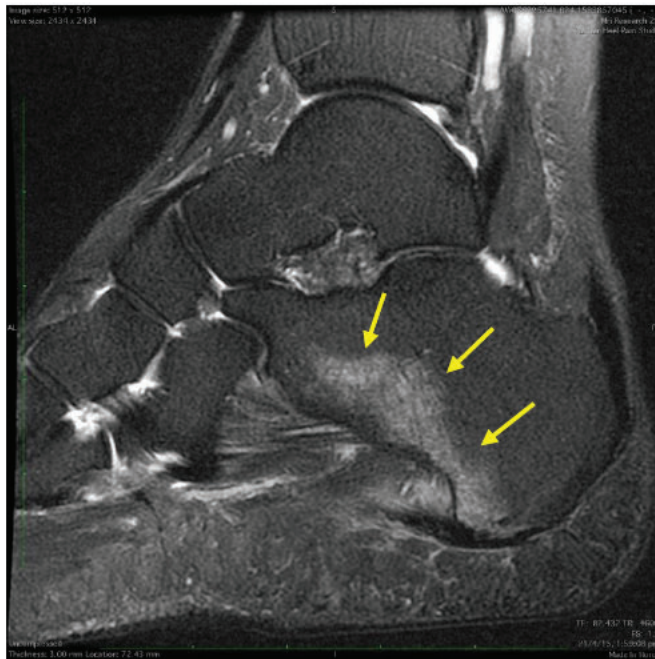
A Calcaneal bone marrow lesion (BML), sagittal T2-weighted sequence, B scored (different participant)
